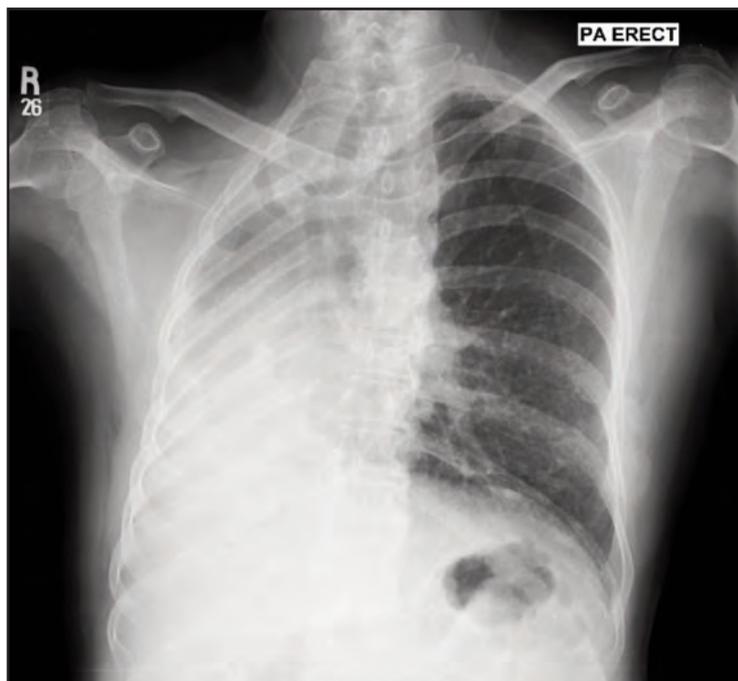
Erect frontal chest radiograph. Complete opaque right hemithorax with crowding of right ribs. Tracheal and mediastinal shift to the right, resulting in the absence of normal left cardiac silhouette. Normal stomach gas bubble position in the left hypochondriac.
